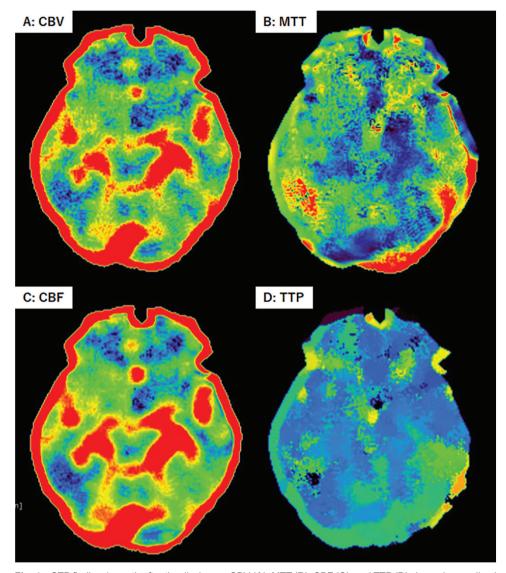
CTP finding 1 month after the discharge, CBV (A), MTT (B), CBF (C), and TTP (D) showed normalized cerebral blood flow. CBF: cerebral blood flow; CBV: cerebral blood volume; CTP: CT perfusion; MTT: mean transit time; TTP: time to peak
